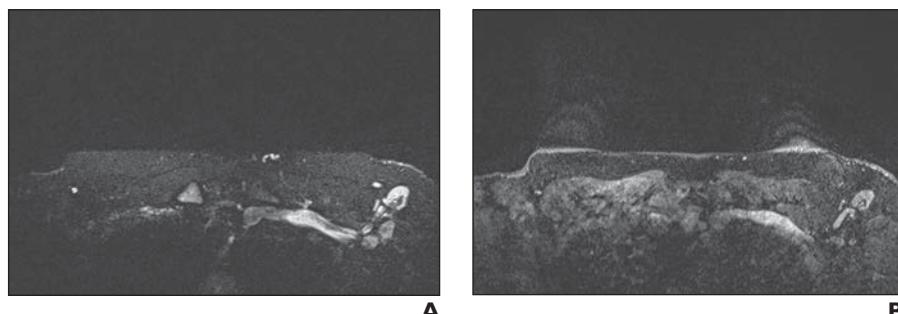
48-year-old woman with *BRCA1* mutation and family history of breast cancer who underwent baseline screening mammography 13 days after receiving first dose of COVID-19 vaccine. A and B, Axial fat-saturated T2-weighted (A) and axial fat-saturated contrast-enhanced T1-weighted (B) MR images show unilateral left level I axillary lymphadenopathy.
